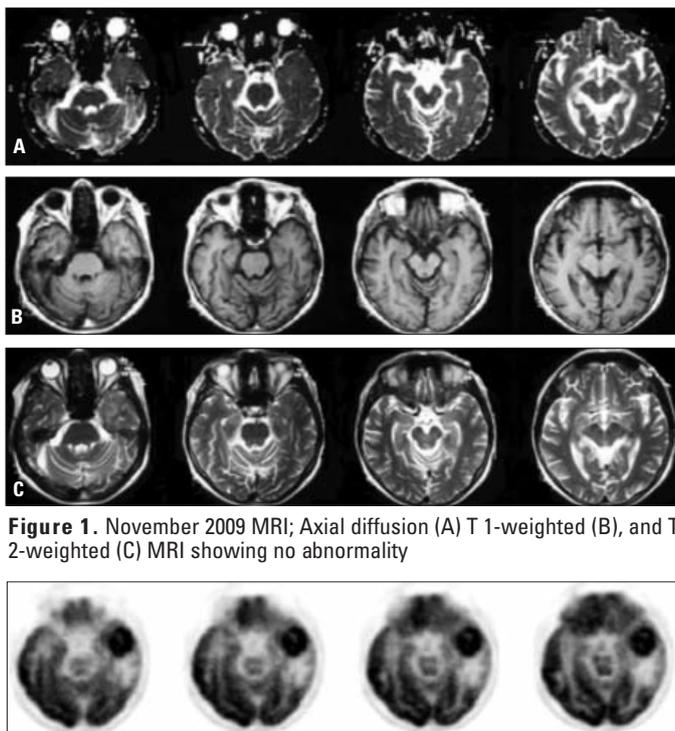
November 2009 MRI; Axial diffusion (A) T 1-weighted (B), and T 2-weighted (C) MRI showing no abnormality
